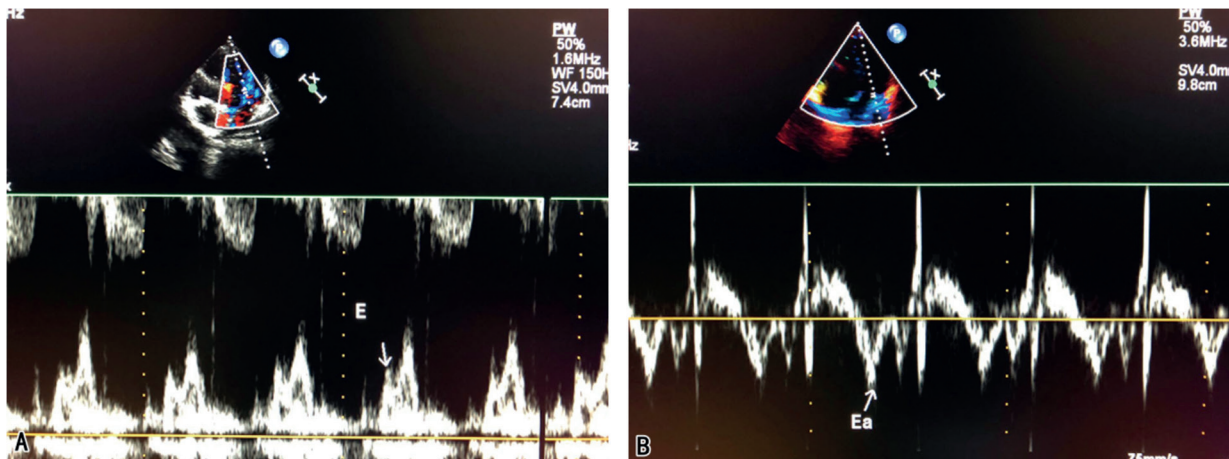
Echocardiographic reexamination of post-operation (A) measurement of mitral valve E peak velocity by Doppler spectrum; (B) TDI measurement of Ea value of mitral annulus.
